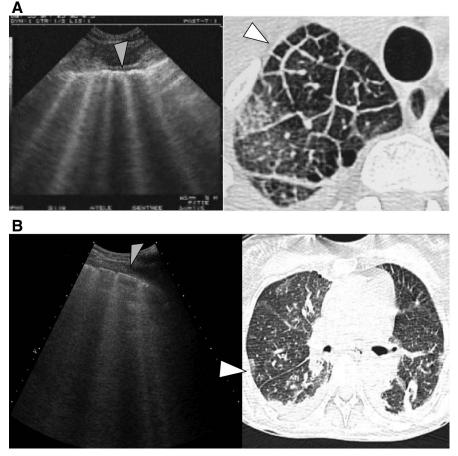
Significance of ultrasound lung comets with regular and irregular spacing. A, 7-mm apart ultrasound lung comets representative of interstitial edema (thickened interlobular septa) and recorded in a patient with cardiogenic pulmonary edema. B, ultrasound lung comets with well-defined and irregular spacing representative of small foci of bronchopneumonia and recorded in a patient with ventilator-associated pneumonia. The white and gray arrows indicate position of the probe.
